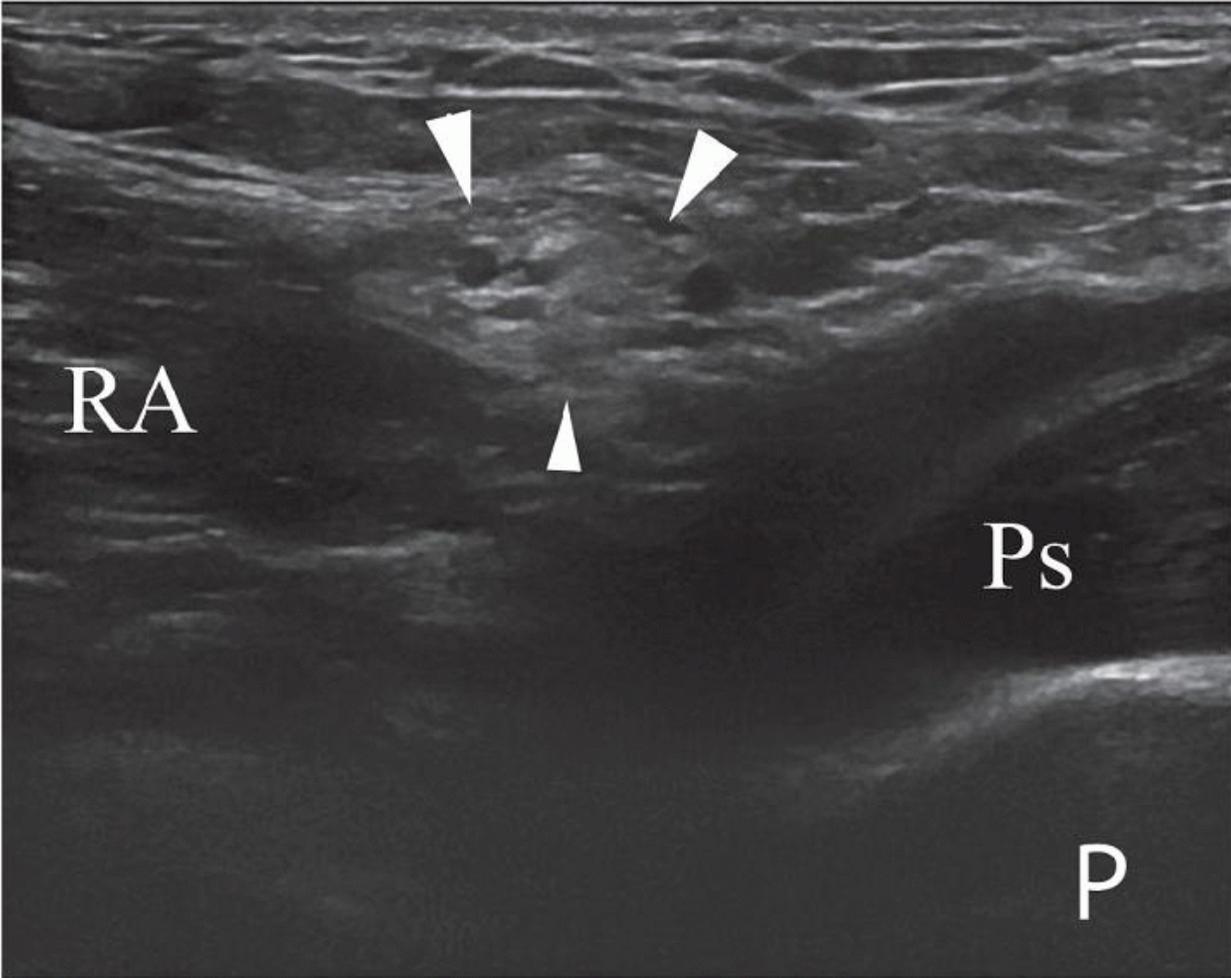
Normal inguinal canal (short axis). Transverse sonogram demonstrates the normal inguinal canal and contents (arrowheads). Iliopsoas muscle (Ps), rectus abdominis (RA), and pubic ramus (P).
